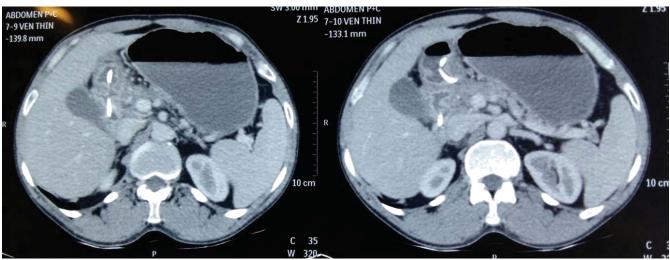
CT abdomen showing no extraluminal leak with migrated stent in the duodenum and pigtail end perforating the wall of pylorus.
